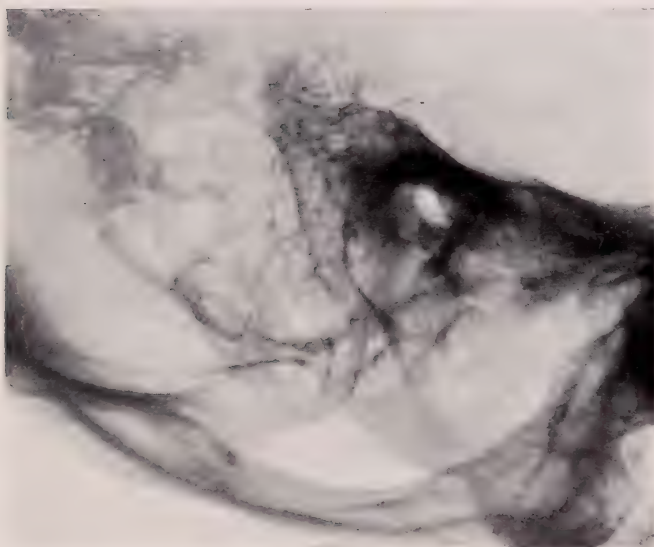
Roentgenogram of the normal dried mastoid showing the mastoid cells, a groove for the lateral sinus and the cells about the petrous portion of the temporal bone.
